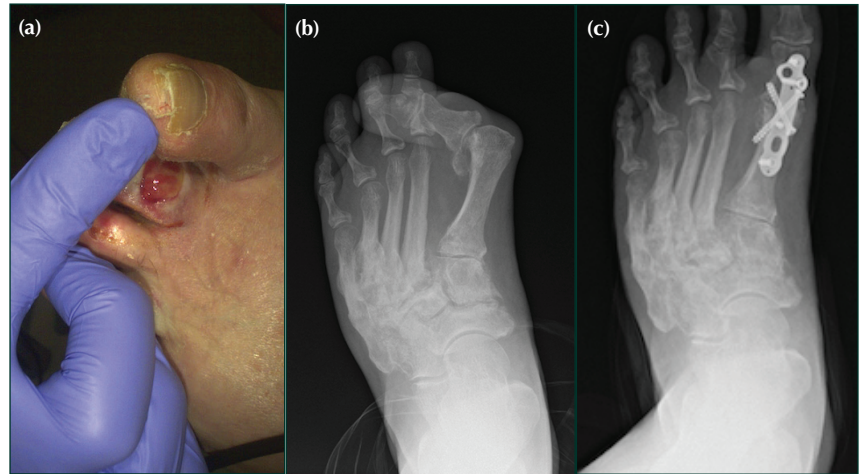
(a, b) Severe hallux valgus deformity causing ulceration of the adjacent toe. (c) Post-operative X-ray following first metatarsophalangeal joint fusion to correct the deformity.
